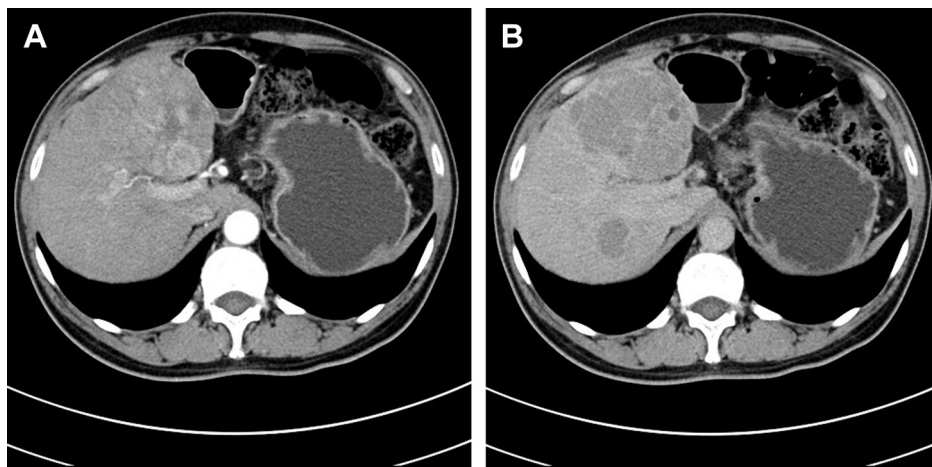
Dynamic computed tomography (CT) images. (A) On the arterial phase image of the dynamic CT, several markedly enhanced masses are present and vary in size with the largest mass approximately 8.2 cm in diameter at S4 of the liver. The center of the tumor is not enhanced and is small necrotic tissue. (B) On the delayed-phase CT images, the tumor shows hypoattenuation.
